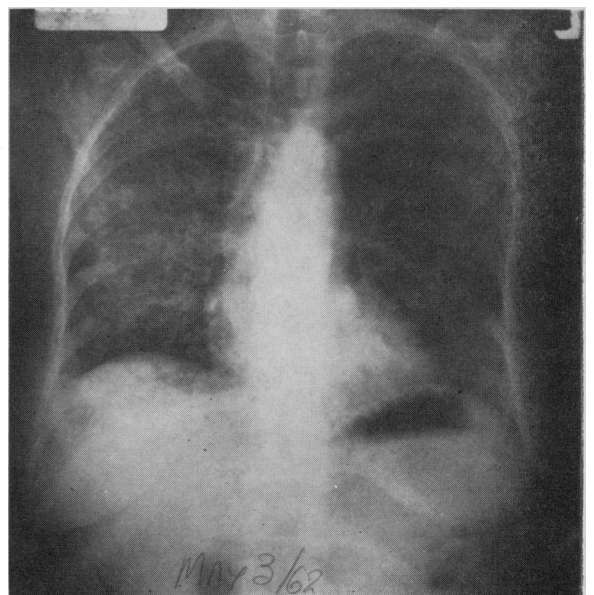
Case 3. Radiograph showing considerable clearing during a period of hospitalization away from antigenic exposure.
